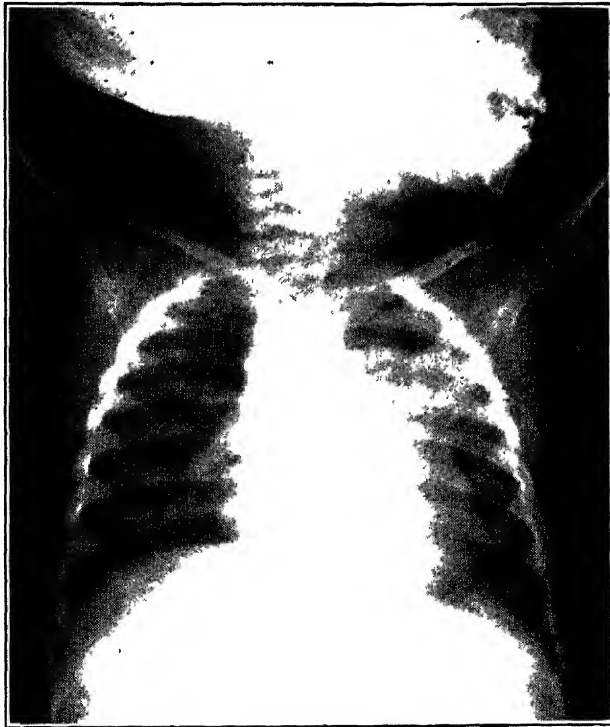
Same case as Fig. 3, roentgenogram taken 7 months later. Shows beginning clearing (Mitchell and Nelson—Ohio State M. J.)
